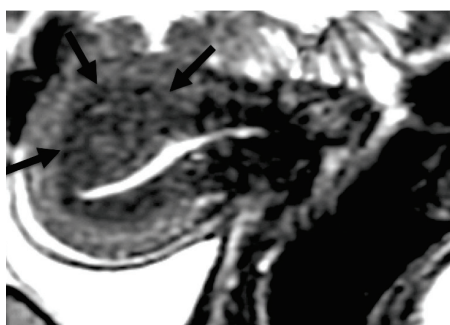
MRI showing adenomyoma before UAE.
